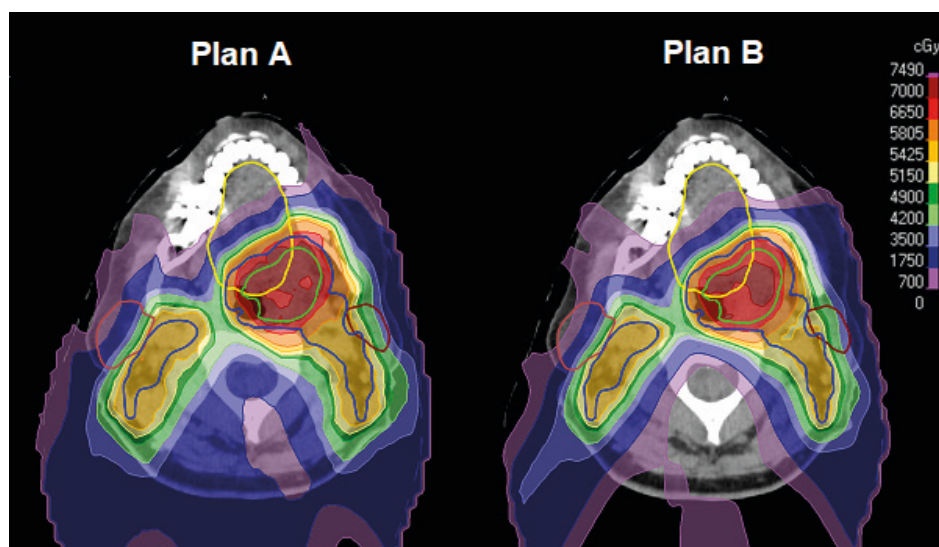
Transversal CT slices showing the nominal dose distribution of “Plan A” (clinical plan) and “Plan B” (automated plan) for a representative case. Structures are labeled as follows: green = CTV7000, dark blue = CTV5425, yellow = oral cavity, and light/dark brown = parotid glands. Target coverage was rated equivalent, whereas Plan B was considered superior in terms of OAR sparing and target conformity. Abbreviations: CT = computed tomography; CTV = clinical target volume; OARs = organs at risk.
